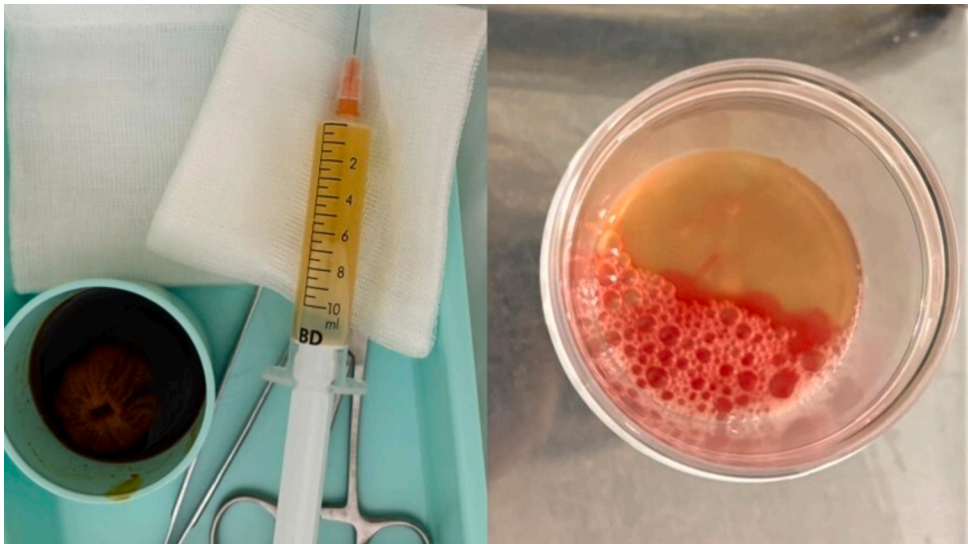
Macroscopic appearance of the joint fluid following ultrasound-guided aspiration, showing cloudy, slightly sero-hematic fluid.
